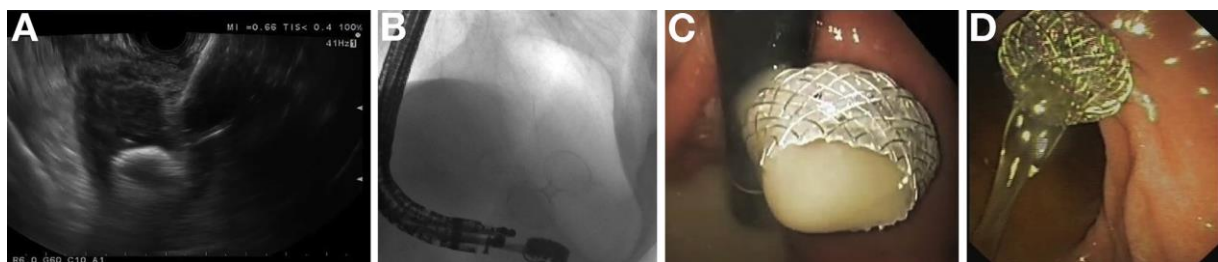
(A) Endoscopic ultrasound showing needle puncture of the pancreatic pseudocyst. (B) Fluoroscopic image showing fully deployed LACSEMS. (C) Endoscopic image showing pus draining through the LACSEMS. (D) Endoscopic image showing pancreatic pseudocyst fluid drainage through the LACSEMS.
